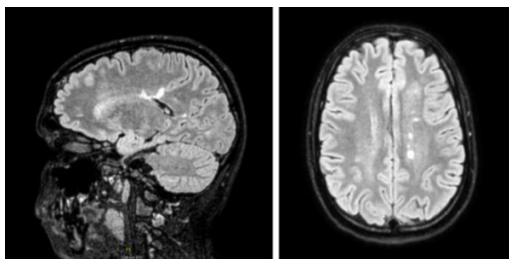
Sagittal FLAIR sequence image demonstrating typical ovoid hyper intensive periventricular lesions (called Dawson fingers). Axial FLAIR sequence image with several periventricular white matter hyper intensive lesions.
